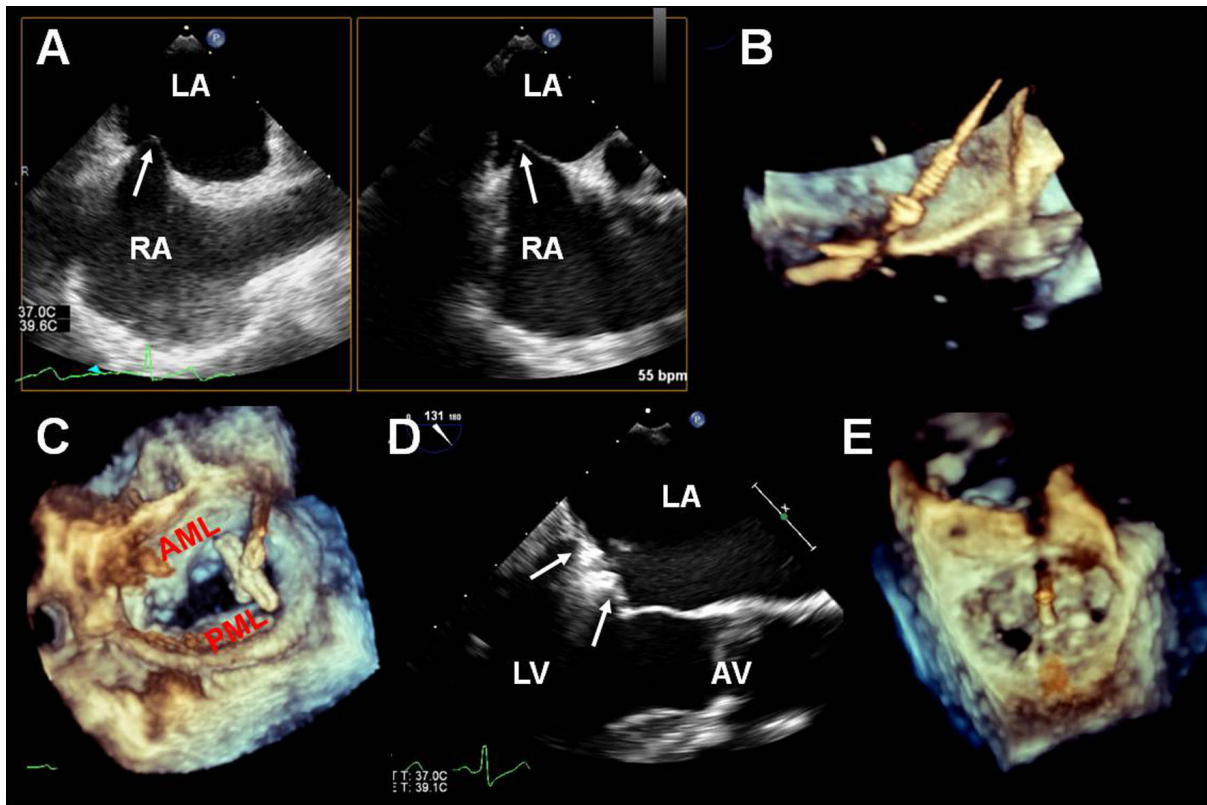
Intra-procedural guidance during MitraClip™ Percutaneous Edge-to-Edge Repair. Transoesophageal echocardiography (TEE) permits localisation of the puncture site of the inter-atrial septum. Tenting of the septum at the fossa ovalis, caused by the trans-septal catheter is clearly appreciated on the simultaneous bi-plane view (the standard bi-caval and the short-axis aortic 2D TEE views in panel A). Constant TEE guidance is necessary for safe manoeuvring throughout the procedure. Real-time 3D TEE depicts clearly the whole guide catheter and dilator (spiral structure) assembly, crossing the septum, away from the surrounding structures (B). Importantly, 3D TEE visualises the mitral valve from the left atrial aspect during positioning of the MitraClip™ above the valve leaflets, to ensure perpendicularity with the coaptation or closure line of the valve for optimal mitral leaflets grasping (C). Adequate grasping of both the mitral leaflets (white arrows) is the key and should be clearly demonstrated on the 2D long-axis TEE view (D). Final appearance is that of a double orifice valve and perpendicularity should be confirmed again using 3D TEE, before full release of the clip (E).
